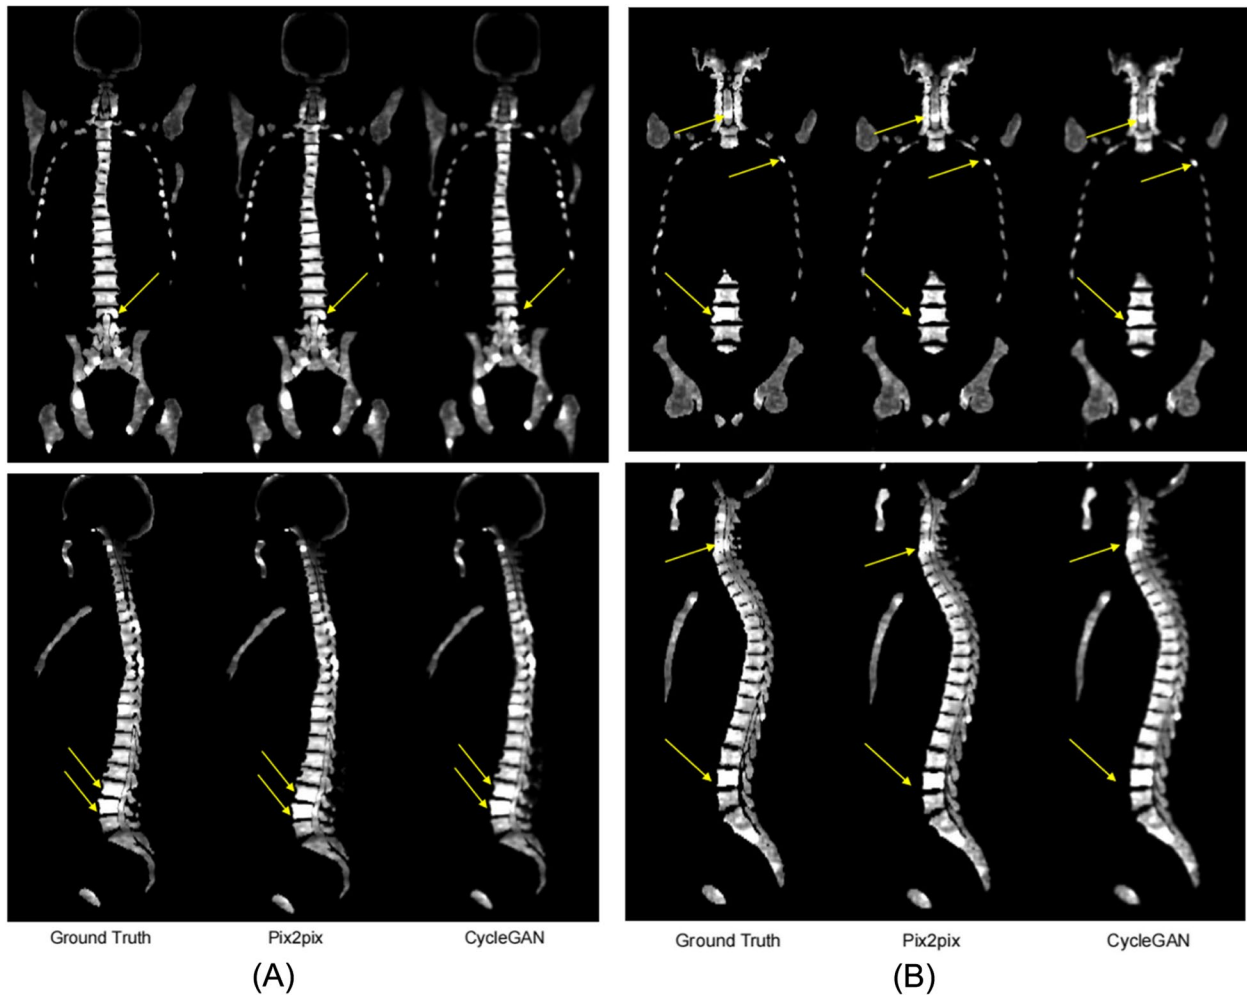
Coronal and sagittal views of [^{18}F]PSMA-1007 WB PET bone image synthesis results for two patients (A) and (B) at stage M
